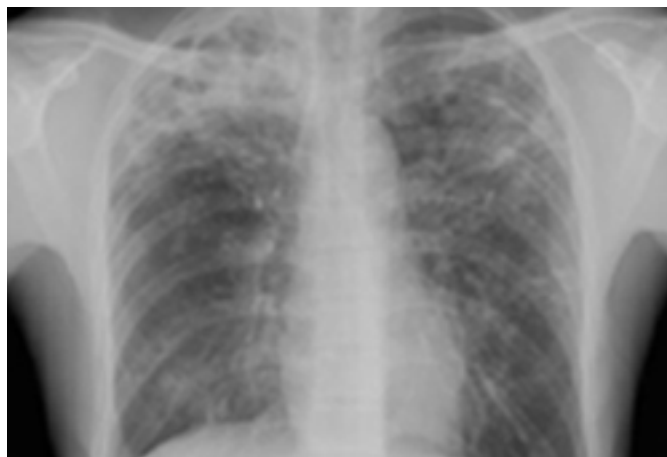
Chest x-ray showing a cavitating right hilar carcinoma (arrow)*
